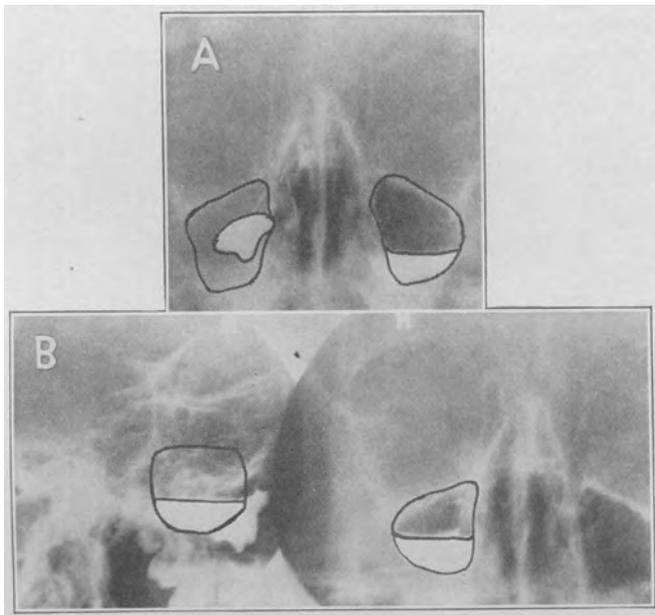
A boy aged 12 was seen by me in September. He had a history of pus discharge from the right side of the nose and cough following a cold in April (seven months previously). He had had nasal treatments and spent some weeks in Florida, hoping to be relieved. There was mucopus in the ethmoid region, and a roentgenogram revealed a marked defect in the filling of the right antrum (A), with clouding of the right ethmoid cells. Oil was again injected five, thirteen, nineteen, twenty-six and thirty-three days after the first injection—a total of six injections of oil. These were followed by a final injection of oil and the making of a roentgenogram three weeks later (B), which showed that recovery was complete.
